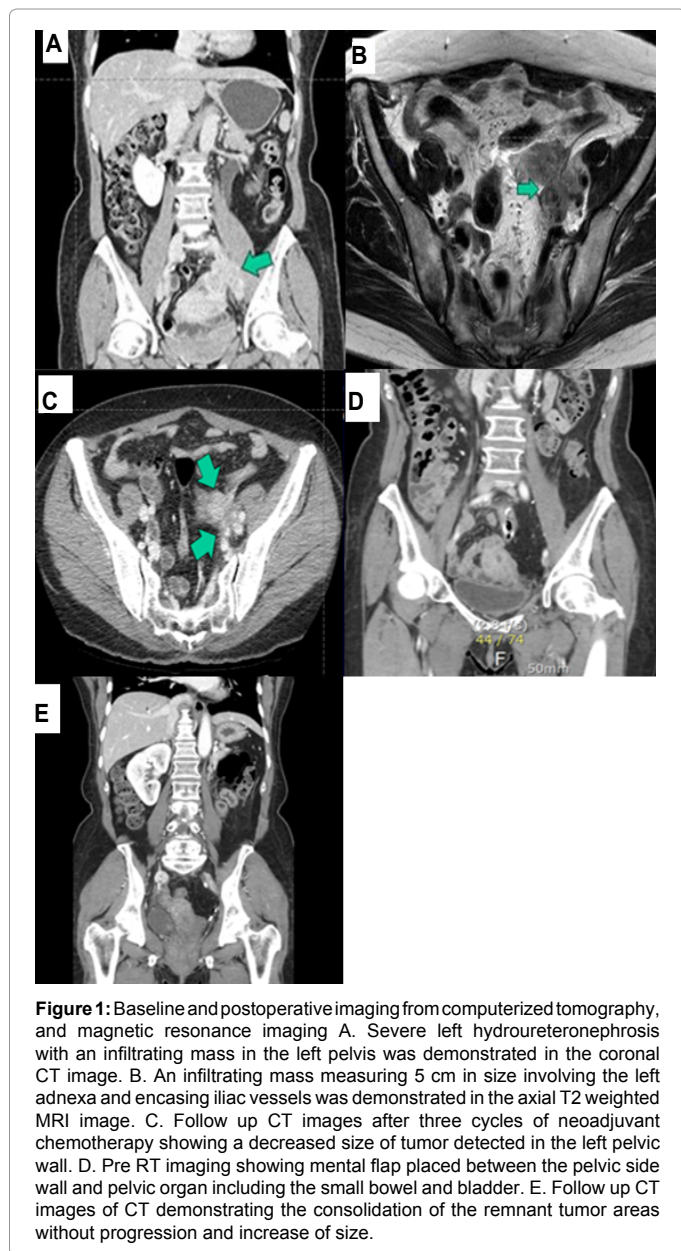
Baseline and postoperative imaging from computerized tomography, and magnetic resonance imaging. A. Severe left hydronephrosis with an infiltrating mass in the left pelvis was demonstrated in the coronal CT image. B. An infiltrating mass measuring 5 cm in size involving the left adnexa and encasing iliac vessels was demonstrated in the axial T2 weighted MRI image. C. Follow up CT images after three cycles of neoadjuvant chemotherapy showing a decreased size of tumor detected in the left pelvic wall. D. Pre RT imaging showing mental flap placed between the pelvic side wall and pelvic organ including the small bowel and bladder. E. Follow up CT images of CT demonstrating the consolidation of the remnant tumor areas without progression and increase of size.
